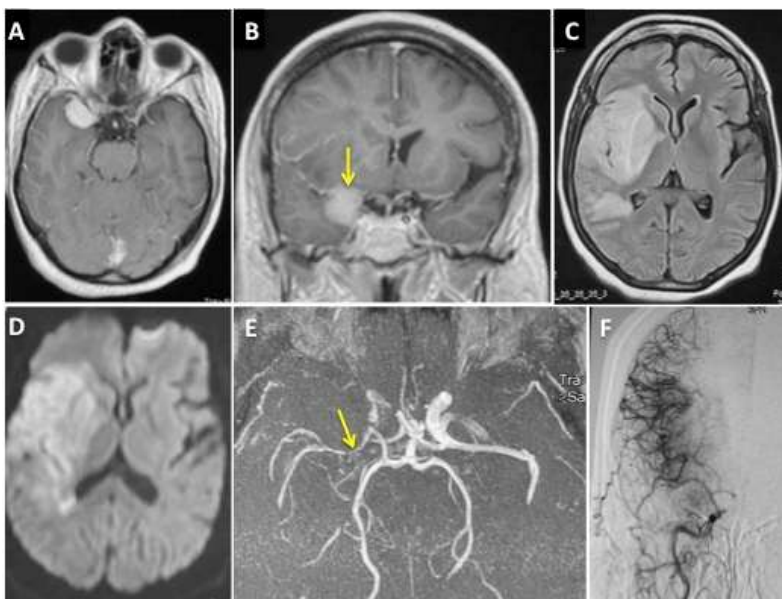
A,B) coronal and axial T1 weighted magnetic resonance images with gadolinium enhancement showing a right sphenoid wing meningioma compressed the first segment of the middle cerebral artery (MCA) (arrow); C,D) axial fluid attenuated inversion recovery images and diffusion-weighted magnetic resonance imaging confirmed acute cerebral infarction in the right MCA territory; E) magnetic resonance angiogram showing stenosis of the M1 segment of the MCA (arrow); F) cerebral angiograph with right internal carotid artery injection demonstrating stenosis of the right proximal M1 portion and radiographic blush from the surrounding meningioma with significant collateral flow to the right MCA territory
